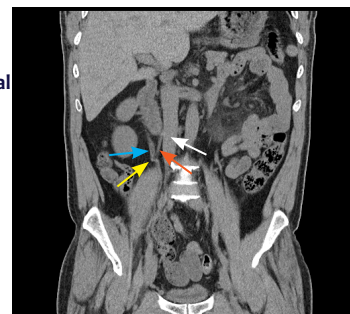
Native CT scan of the abdomen coronal section
